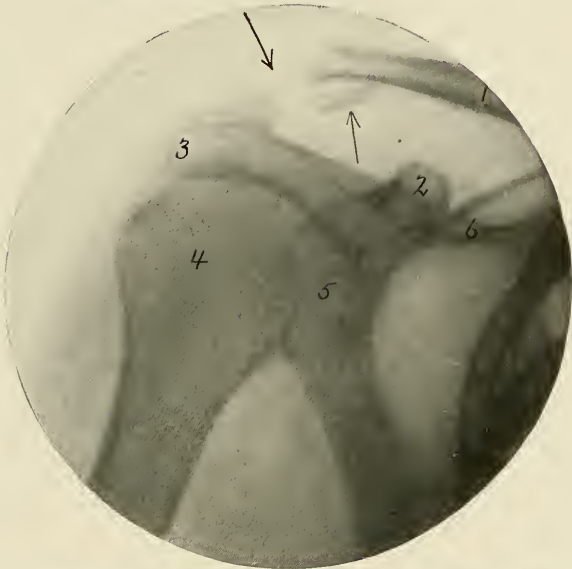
Dislocation of the acromioclavicular joint. X-ray appearance of a case before operation. 1, clavicle; 2, coracoid process; 3, acromion process; 4, head of humerus; 5, glenoid cavity of the scapula; 6, spine of the scapula. The upper arrow points to the acromioclavicular joint. The lower arrow points to the periosteum stripped off of the under surface of the clavicle.
